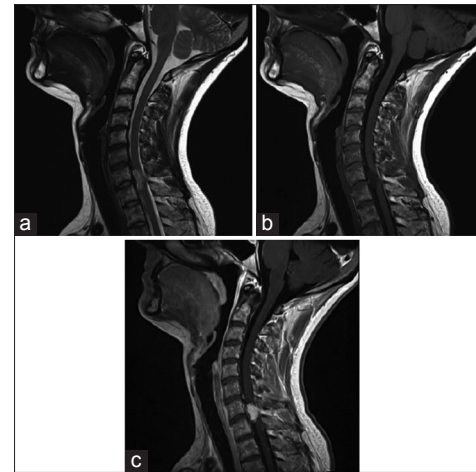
Magnetic resonance imaging C spine. Sagittal slices demonstrates lesion on T2 (a), T1 (b), and T1 with contrast (c)
